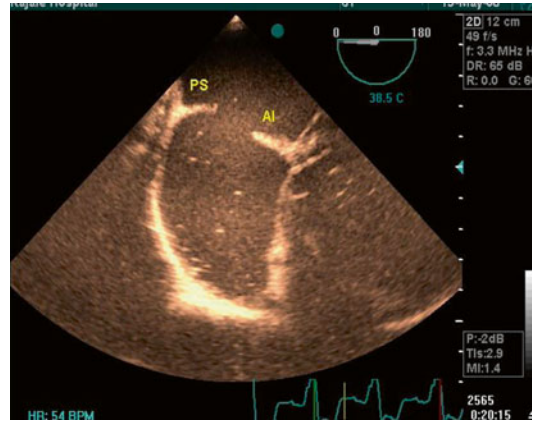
Transesophageal echocardiography in four-chamber view showing the mitral or anteroinferior rim *AI* and posteriosuperior *PS* rims
